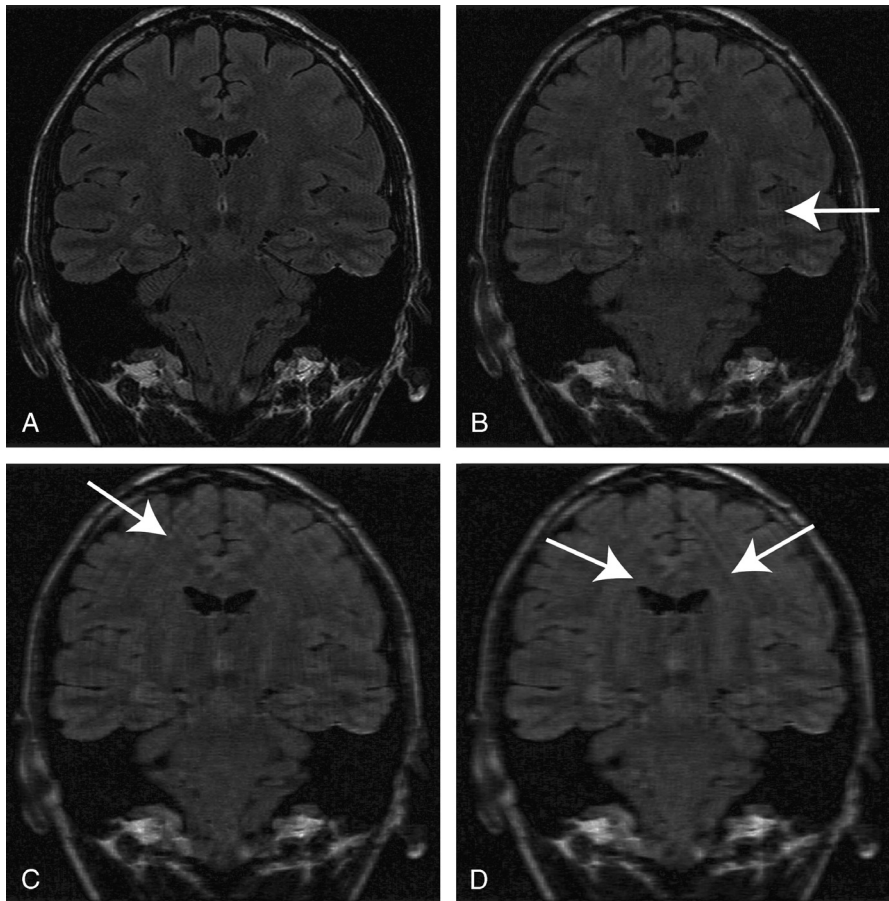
T2-FLAIR images reconstructed using (A) fully sampled RSS; scan time is 5 minutes 12 seconds. B, 2 \times -accelerated CS followed by RSS; effective scan time is 2 minutes 36 seconds. C, 3 \times -accelerated CS followed by RSS; effective scan time is 1 minute 44 seconds. D, 4 \times -accelerated CS followed by RSS; effective scan time is 1 minute 18 seconds. The white arrows highlight areas in which the global ringing artifact was most apparent. There is also a significant blurring of fine-scale image features as the acceleration factor increases.
